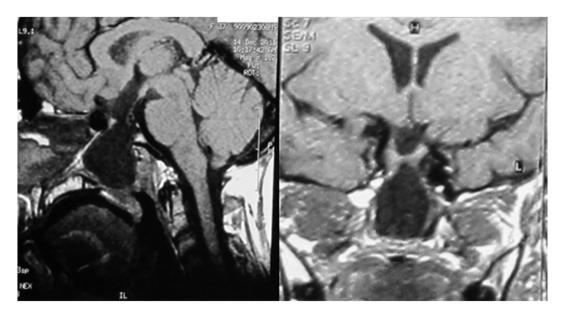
Sagittal and Coronal T 1-weighted MRI showing the meningoencephalocele positioned posterior to the chiasma and the 3rd ventricle involvement and extension of the lesion to the nasopharynx.
